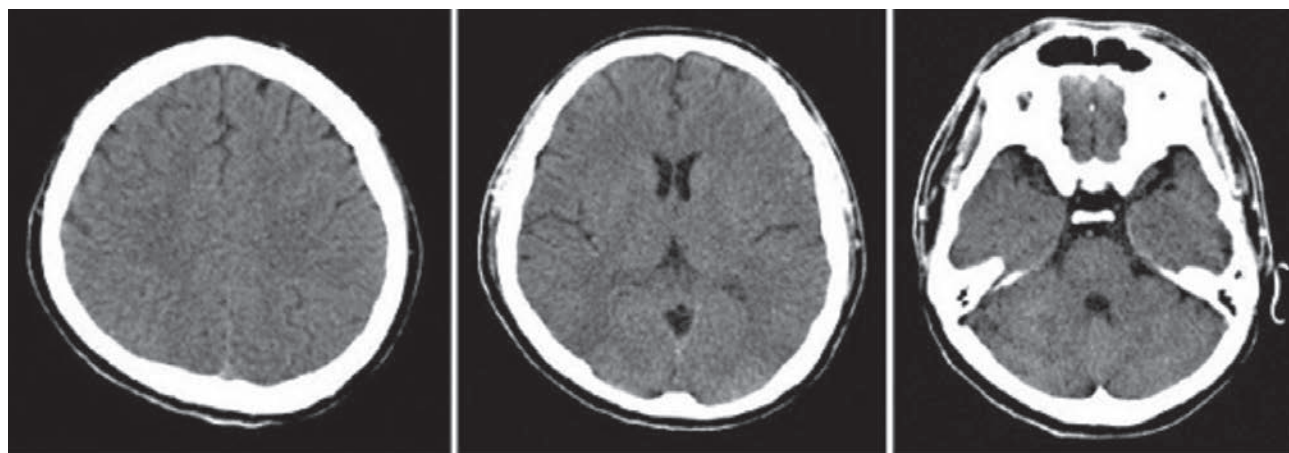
CT scan of the brain showing no significant abnormalities.
